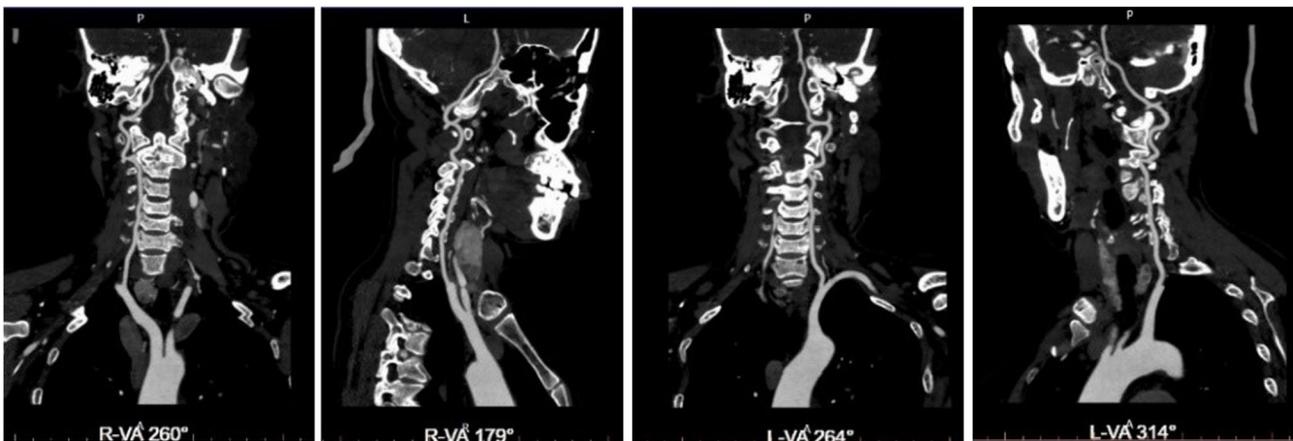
Head and neck CT angiography 3 days after initial admission.
